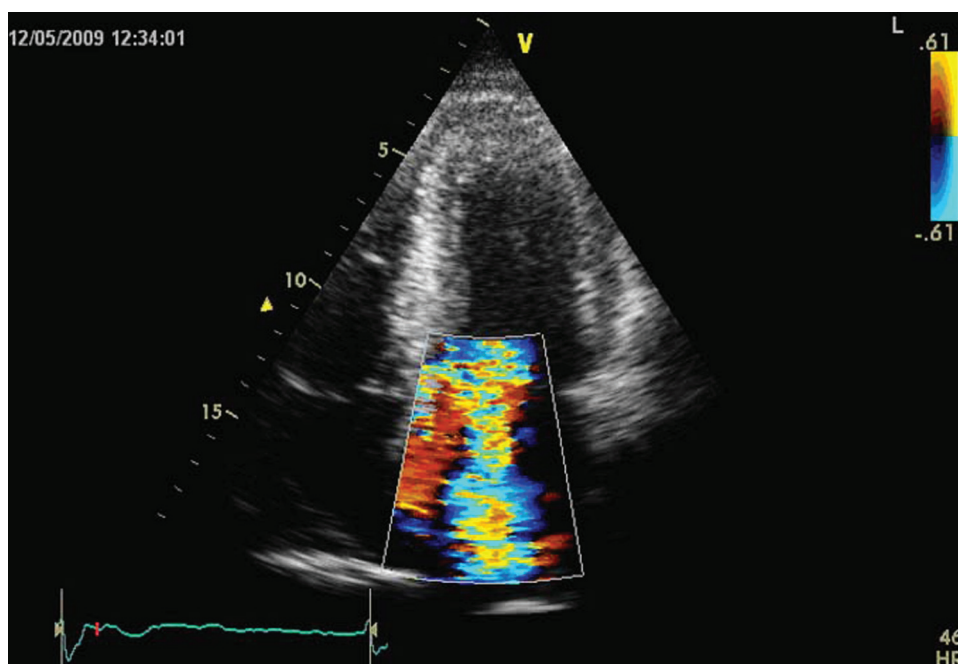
Colour Doppler showing severe class IV mitral regurgitation.
